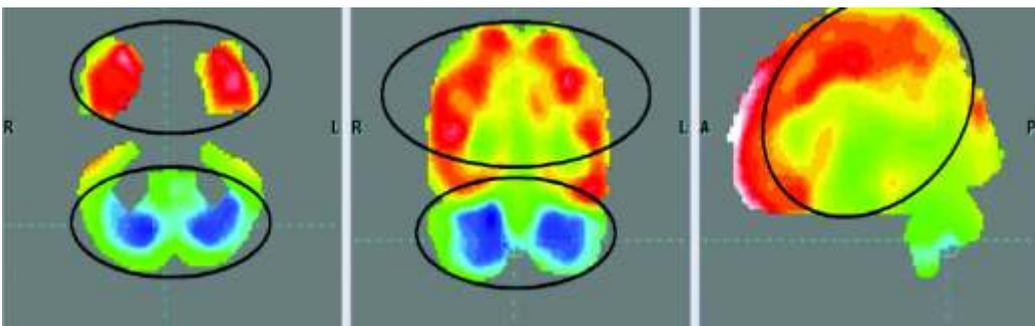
PET-CT scan before stem cell therapy showing diffuse increase in the metabolic activity of the cortical lobes and reduced metabolic activity in bilateral cerebellar lobes
